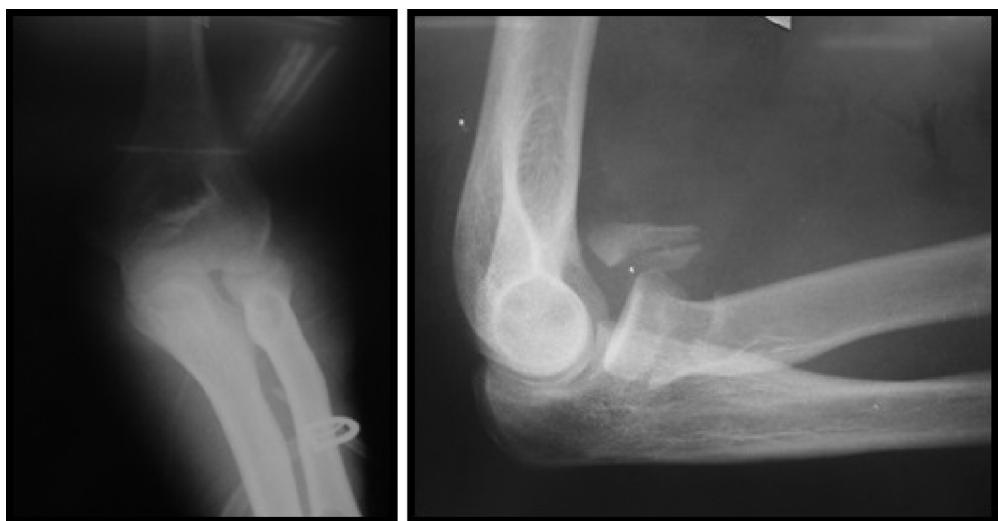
Radiographs showing the terrible triad of the elbow.
